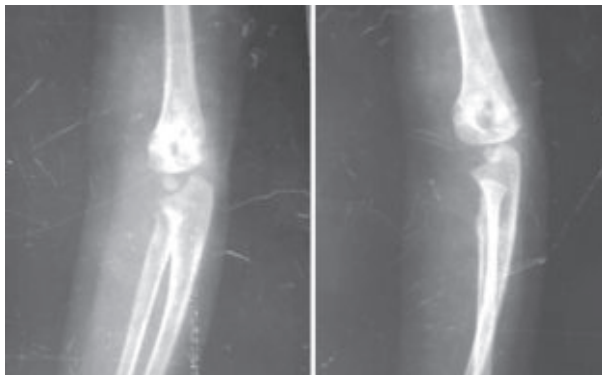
Follow up x-ray of 8 years old boy
